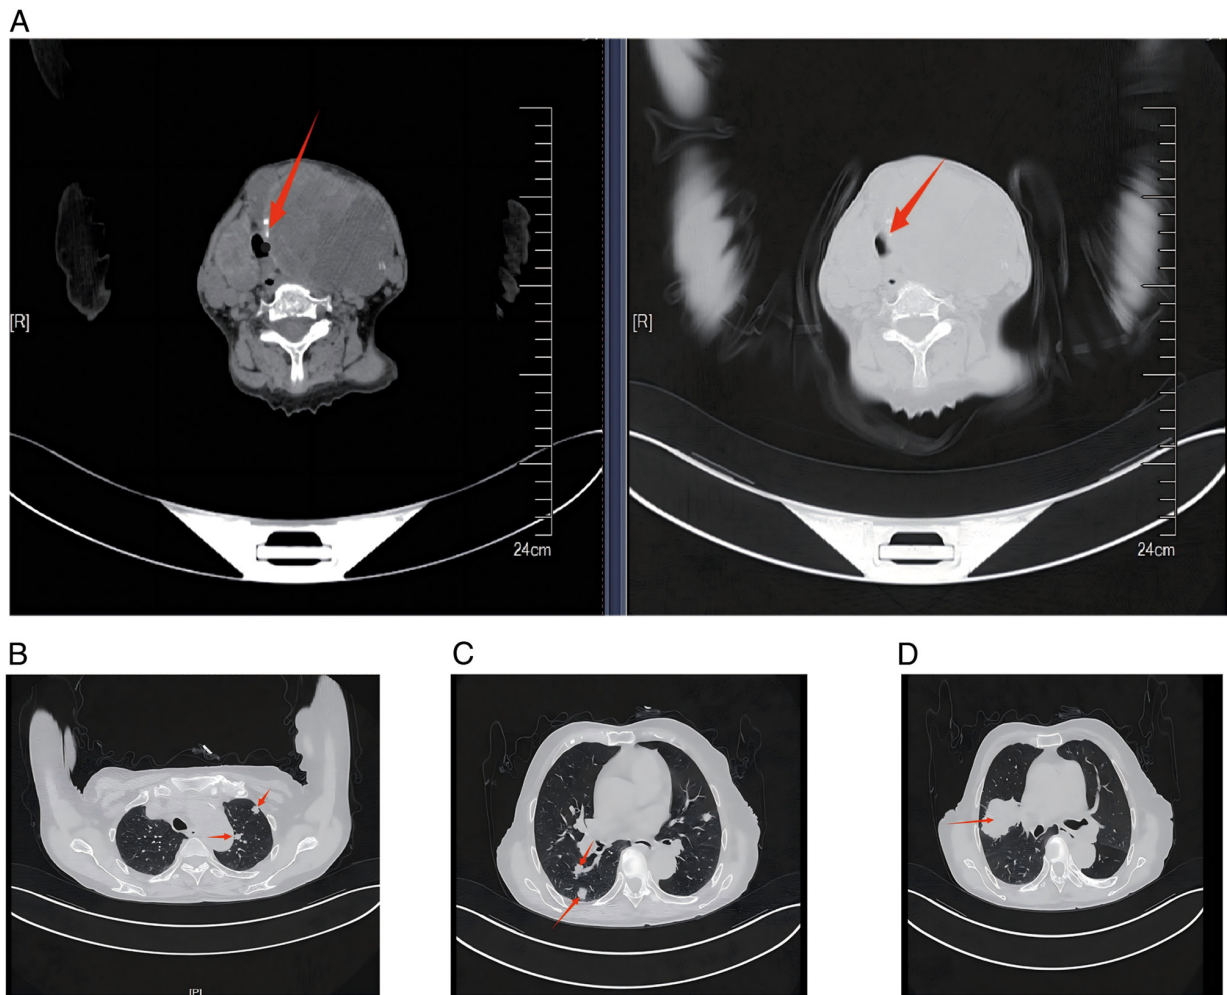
CT findings of the thyroid mass and pulmonary metastases. (A) Paired axial CT images of the neck obtained using different window settings showing a markedly enlarged left thyroid mass causing severe compression, narrowing and rightward displacement of the tracheal lumen; the arrows indicate the compressed trachea. (B-D) Representative axial chest CT images showing multiple bilateral pulmonary nodules and masses (arrows), suggestive of metastatic disease. CT, computed tomography.
